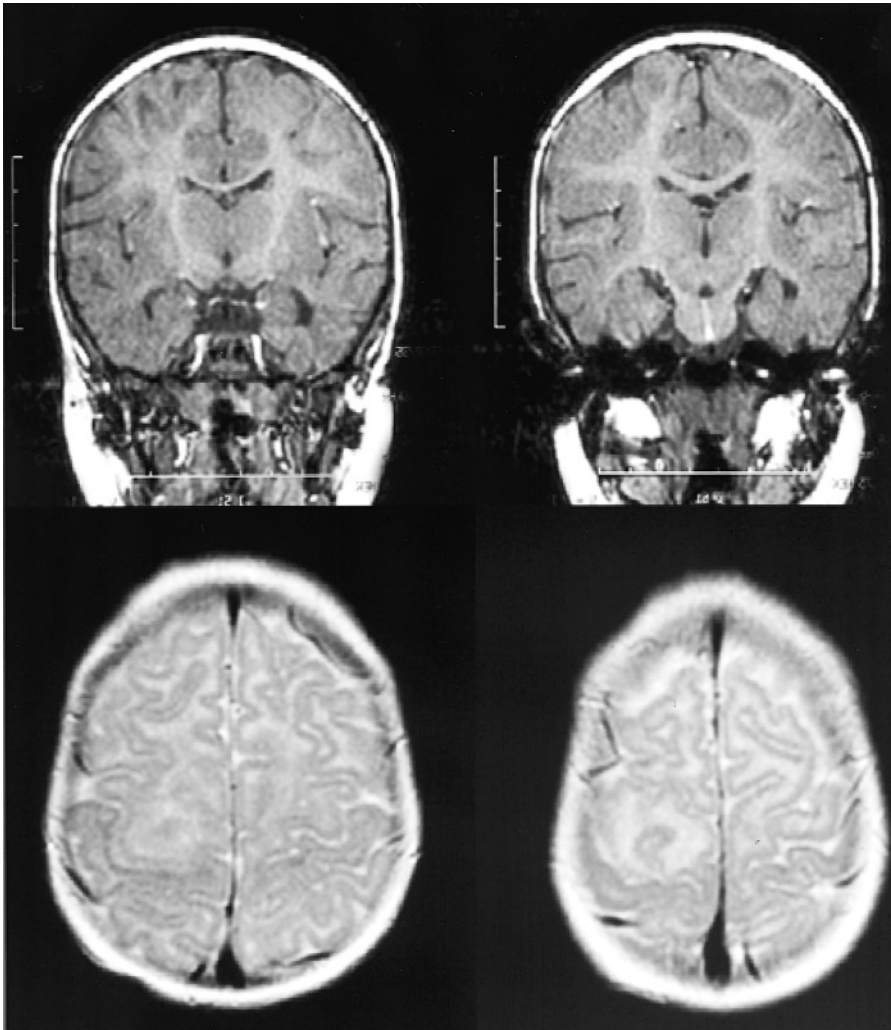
Focal cortical dysplasia. Upper panels show coronal T_1 -weighted magnetic resonance image with the corresponding, lower panel, axial T_2 -weighted sequence showing a right frontoparietal focal cortical dysplasia lesion.
